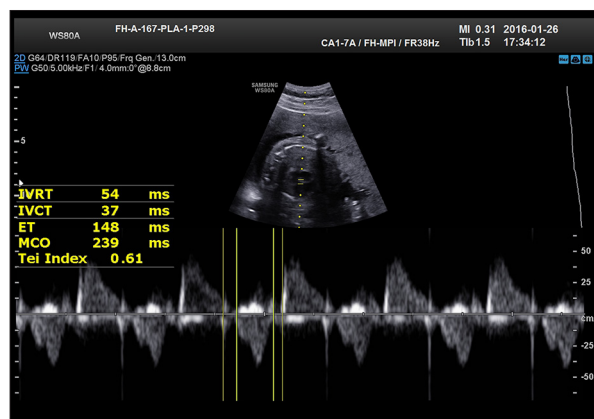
Abnormal myocardial performance index Doppler tracing at the mitral valve.
